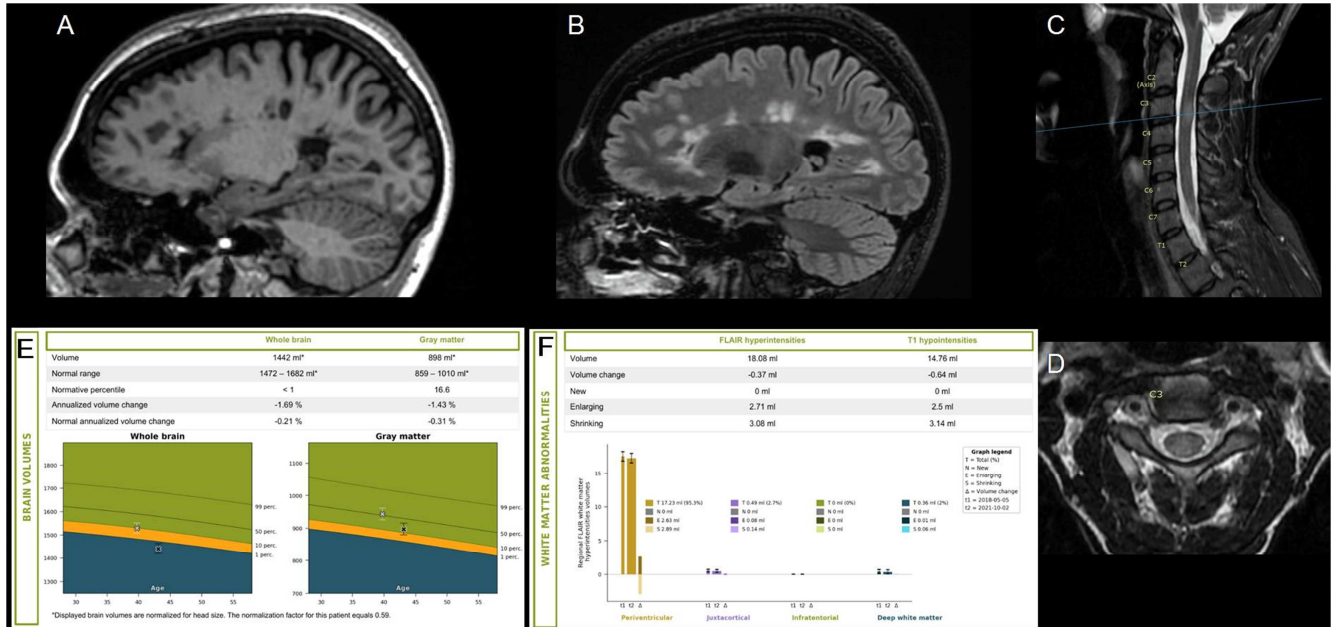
Magnetic resonance imaging (MRI) sequences demonstrating the distribution of multiple sclerosis (MS) lesions seen in this patient. A, Sagittal T1-weighted and B, Fluid Attenuated Inversion Recovery (FLAIR) sequences demonstrate classic “Dawson’s fingers” periventricular lesions. C, Sagittal Short Tau Inversion Recovery (STIR) and D, Axial T2-weighted sequences demonstrate an MS plaque at the C3-C4 level. E-F, Quantified MRI reports demonstrating rapid loss of brain volume of approximating 1.7% annually (E) and unchanged lesion burden (F) in the interval between the two time points.
